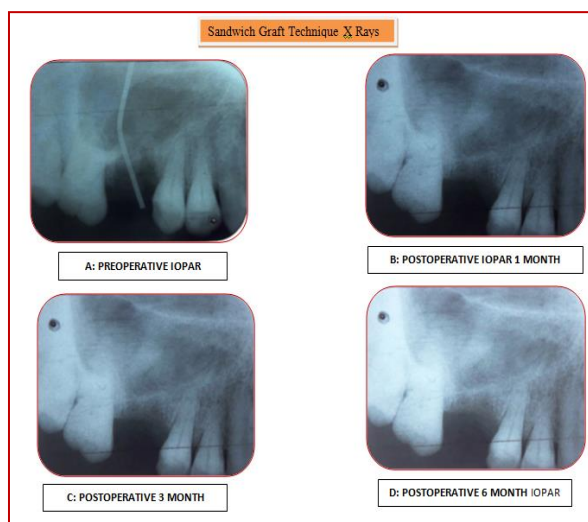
Showing sandwich graft technique X-rays from A to D
